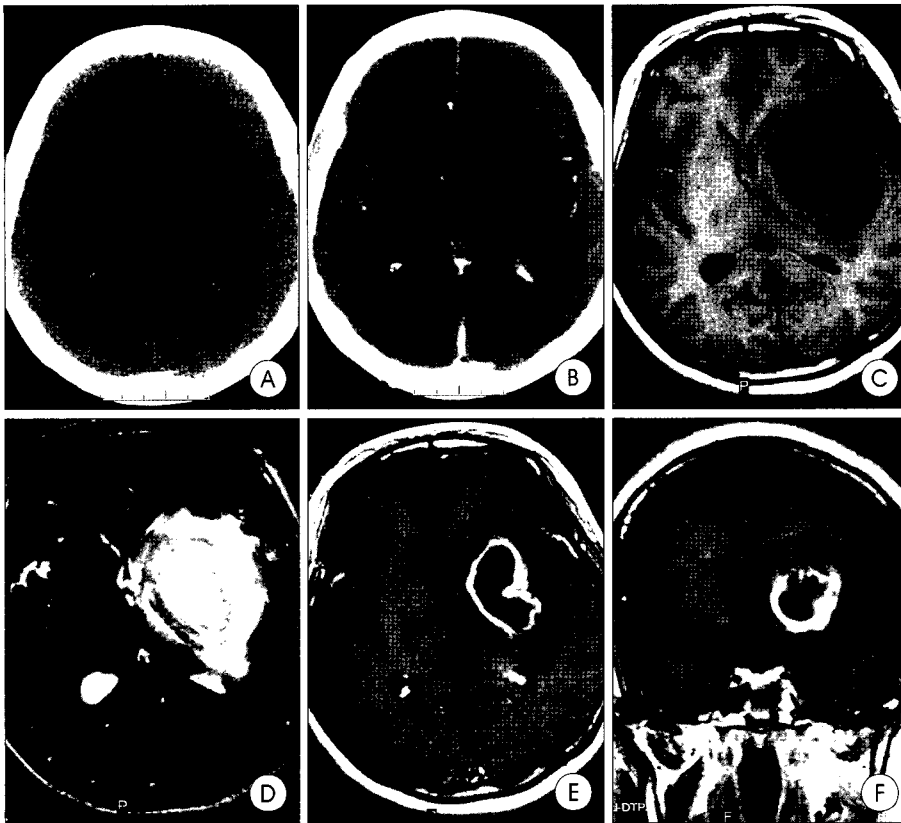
Precontrast brain computed tomography (A) shows mass-like isodensity with peripheral low density on left temporal lobe. Also, midline shifting to right side and sulci effacement are seen. Contrast-enhanced view (B) shows well enhanced peripheral rim. Brain magnetic resonance image shows mass-like lesion with low signal intensity on the left temporal lobe at T1-axial image (C) and high signal intensity at T2-axial image (D). Gadolinium-enhanced axial (E) and coronal (F) images show well homogeneously enhancing peripheral ring around central lesion.
